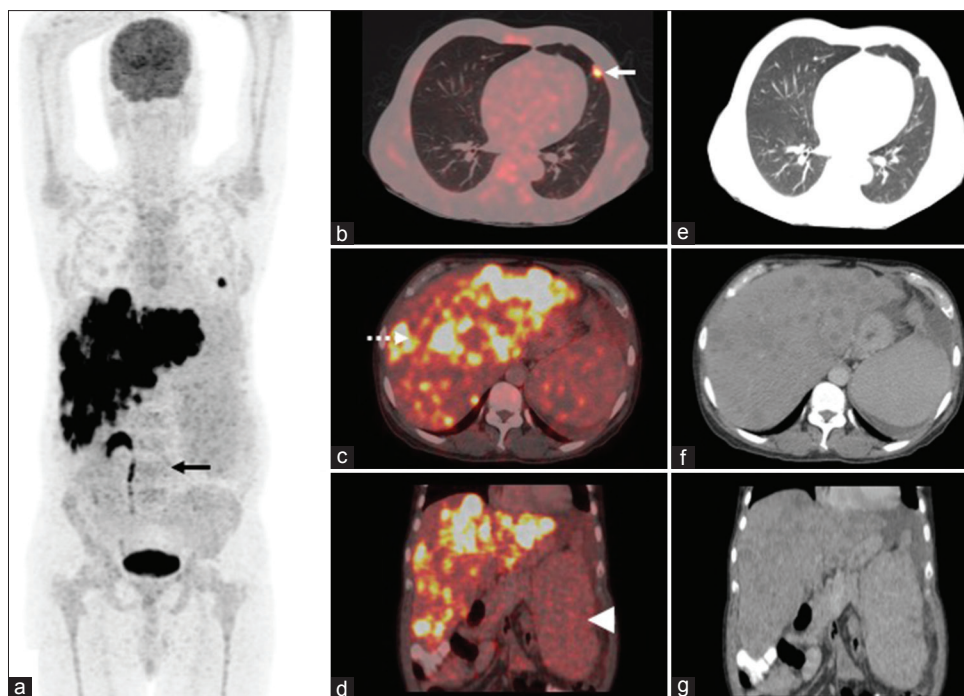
18F-labeled fluoro-2-deoxyglucose PET/CT; Maximum intensity projection image (a) of positron-emission tomography shows focal increased fluoro-2-deoxyglucose uptake in the left hemithorax and multiple areas of increased tracer uptake in the liver. PET/CT fused (trans-axial [b and c] and coronal [d]) and CT-images (transaxial [e and f] and coronal [g]) revealed intense fluoro-2-deoxyglucose uptake in pleural-based nodule in the left lung lower lobe ([b]: arrow) and intensely fluoro-2-deoxyglucose-avid multiple hypodense lesions in enlarged liver ([c]: dashed arrow). Note was also made of mild heterogeneous tracer uptake in the marrow ([a]: black arrow) and enlarged spleen with no abnormal fluoro-2-deoxyglucose uptake ([d]: arrowhead)
